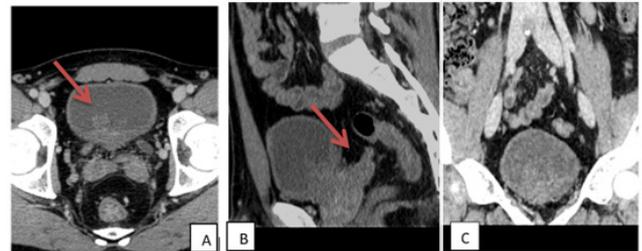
Contrast enhanced CT images of urinary bladder Axial (A) Sagittal (B) and Coronal (C) showing polypoidal enhancing mass arising from base of urinary bladder.
